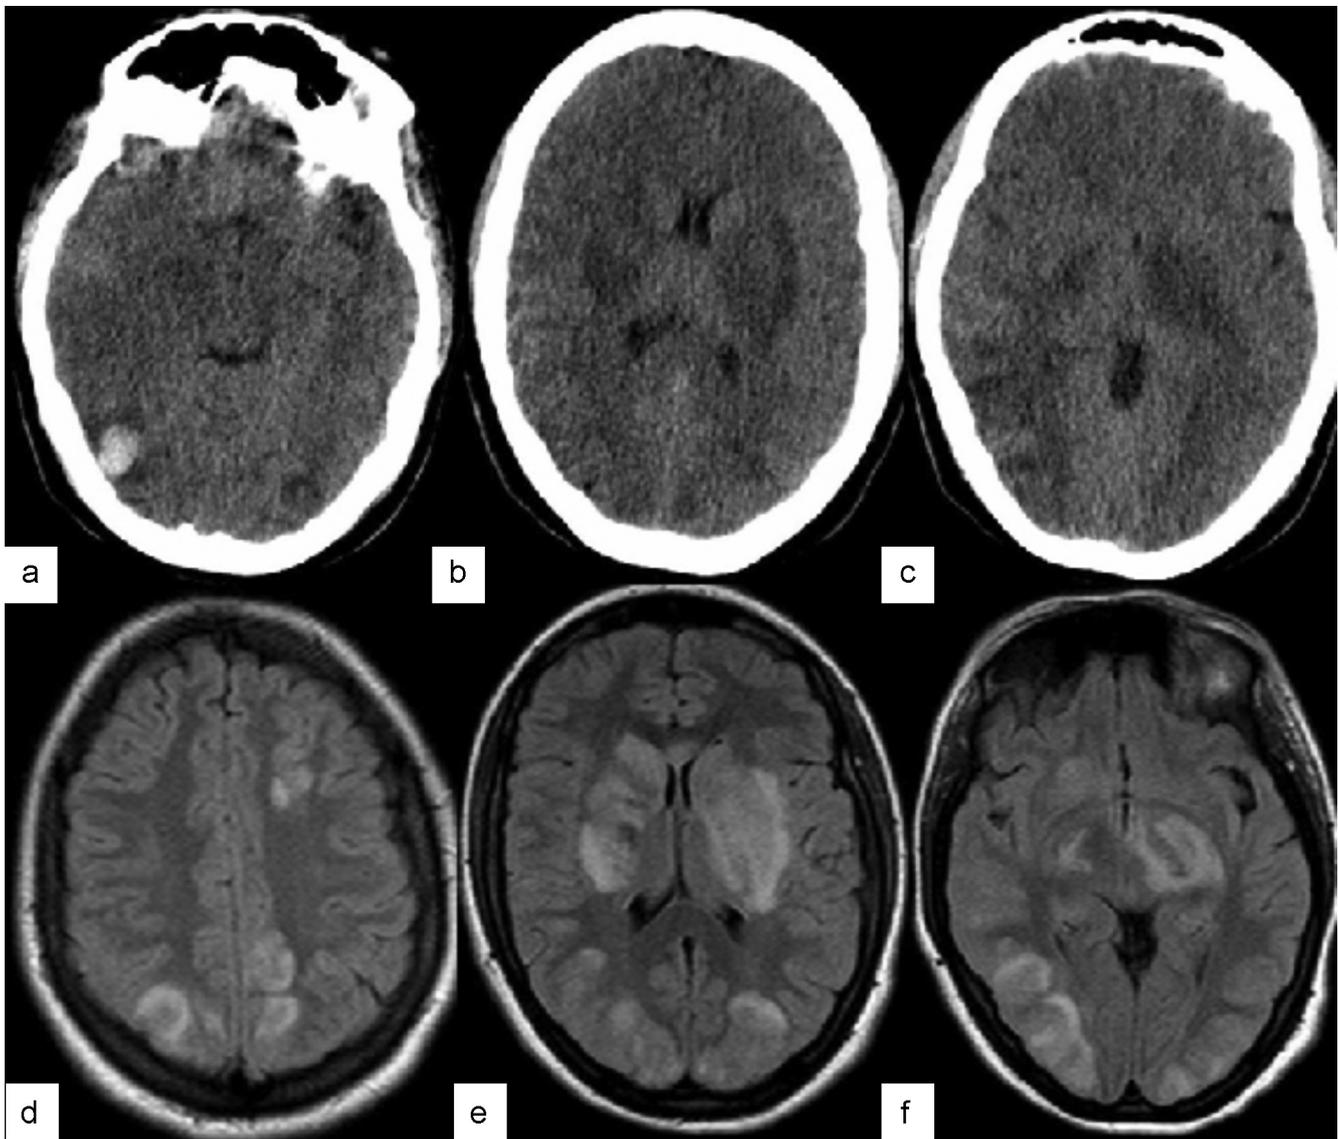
Axial CT (a)–(c) and MR (d)–(f) images on the 2nd day the hematoma in the right hemisphere, density and signal abnormalities expanded, and became more evident, contrarily subarachnoid hemorrhage disappeared.
